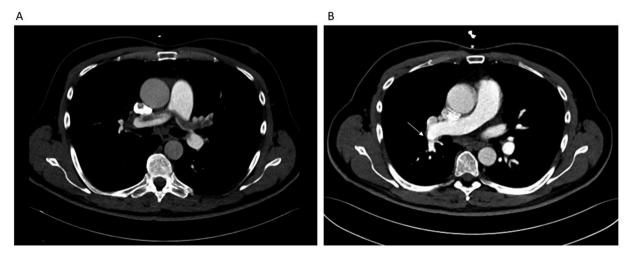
Computed tomography pulmonary angiography (CTPA) cross-sectional view at the level of the main pulmonary artery bifurcation. (A) Acute PE in 2020. (B) Follow-up CTPA in 2022 showing complete clearance of the central thrombus. There is a web lesion on this section as a sign for chronic disease (white arrow).
